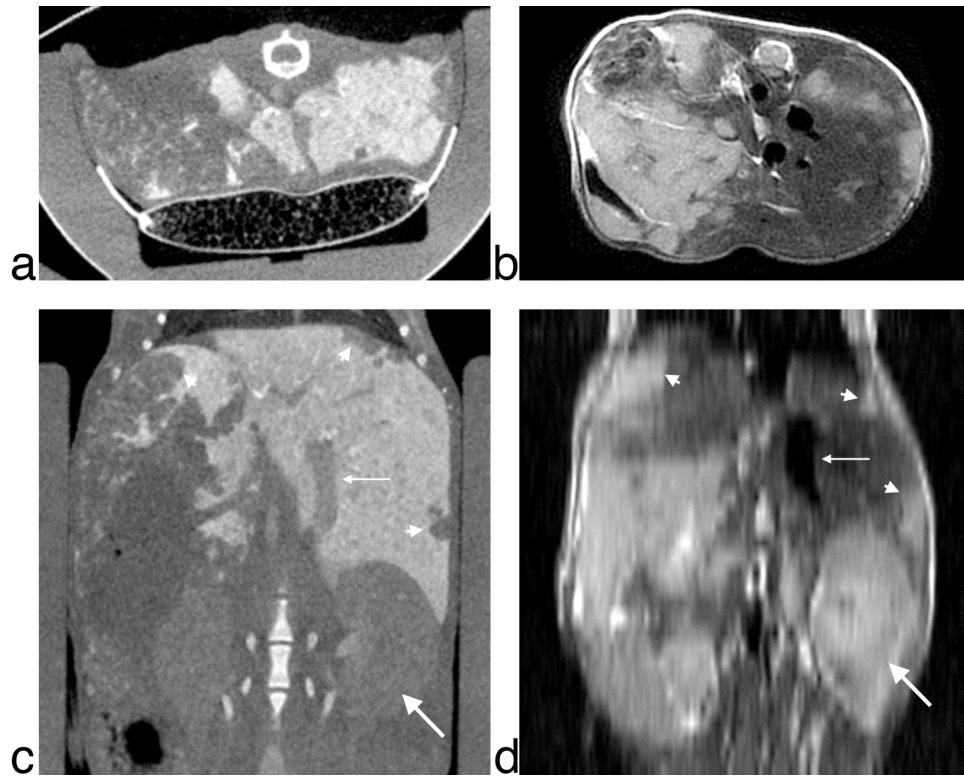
Axial dataset (a, b) along with coronal resection (c, d) with CT and MR respectively. The coronal section shows the left kidney (thick arrow), the inferior vena cava (thin arrow) and multiple tumor nodules (arrowheads).
